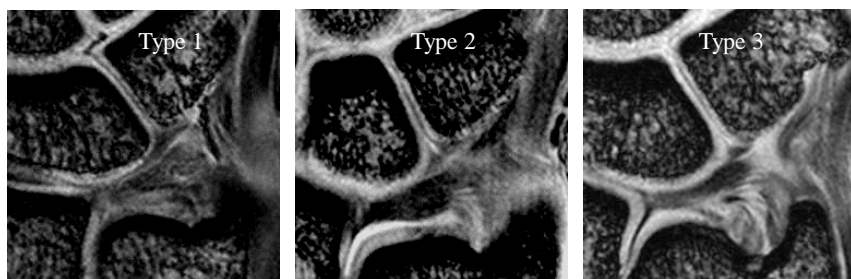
High-resolution MRI of signal intensity of LTL proximal zone
